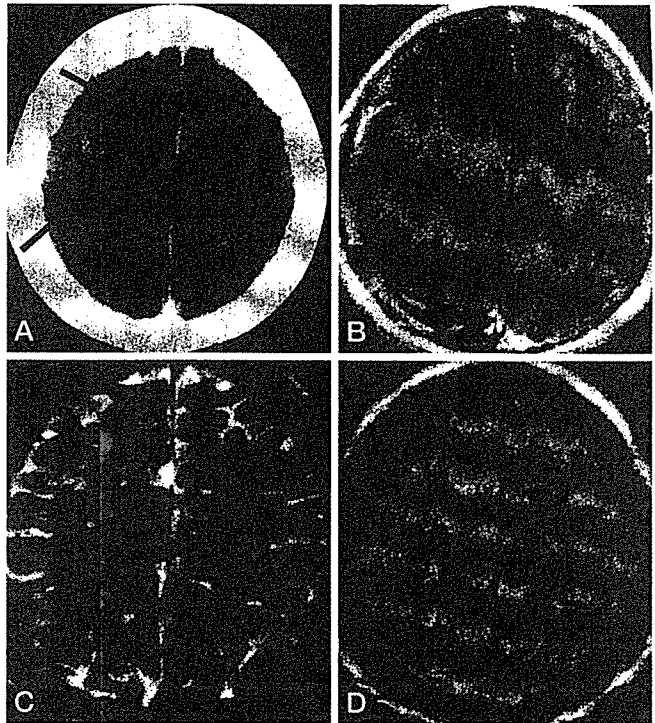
A and B : Heavily T2 weighted (black and white) inverted axial and coronal MR images. The lesions consisted of two components; linear or small oval CSF signal intensity (arrow) and surrounding edema-like changes, which seemed to be located in the white matter. The linear and small ovoid parts conformed to the pathways of the medullary arteries (Fig. 9C). This strongly supports that the low signal intensities are related to the perivascular spaces. C : Microangiography of cerebral hemisphere from reference 38. Medullary arteries, conforming to the low signal intensity in the cerebral cortex in Fig. 9B, are clearly shown.
